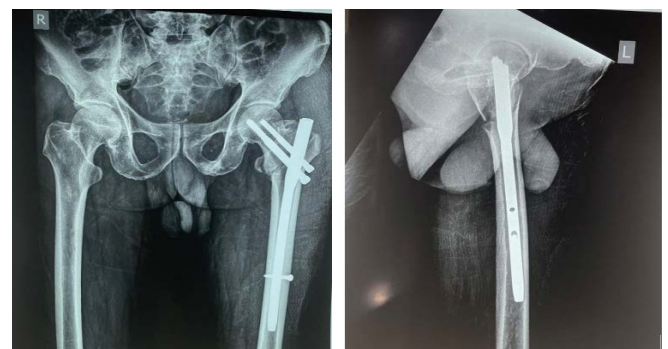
Post-op X-ray film of patient managed with standard PFN.
